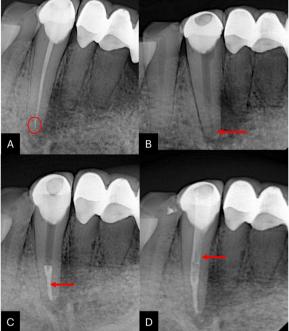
A Pre operative radiograph showing separated instrument indicated by red circle; B Radiograph post instrument retrieval indicated by red arrow; C Sectional obturation indicated by red arrow; D Anatomic post indicated by red arrow
